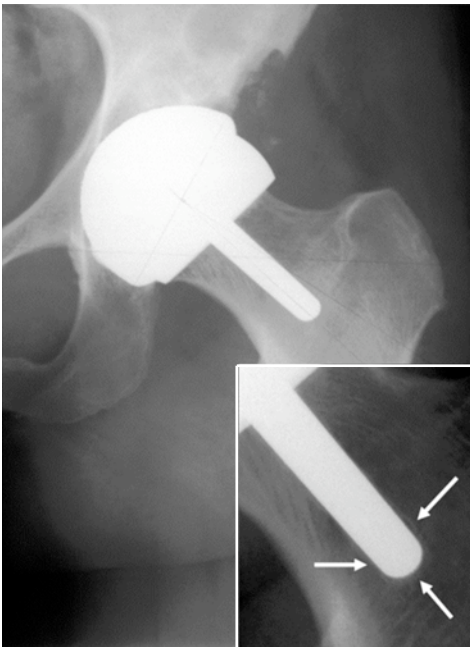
Hip radiograph of a 58 year old woman, made 47 months after BHR arthroplasty, showing femoral radiolucencies around the tip of the metaphyseal stem.
